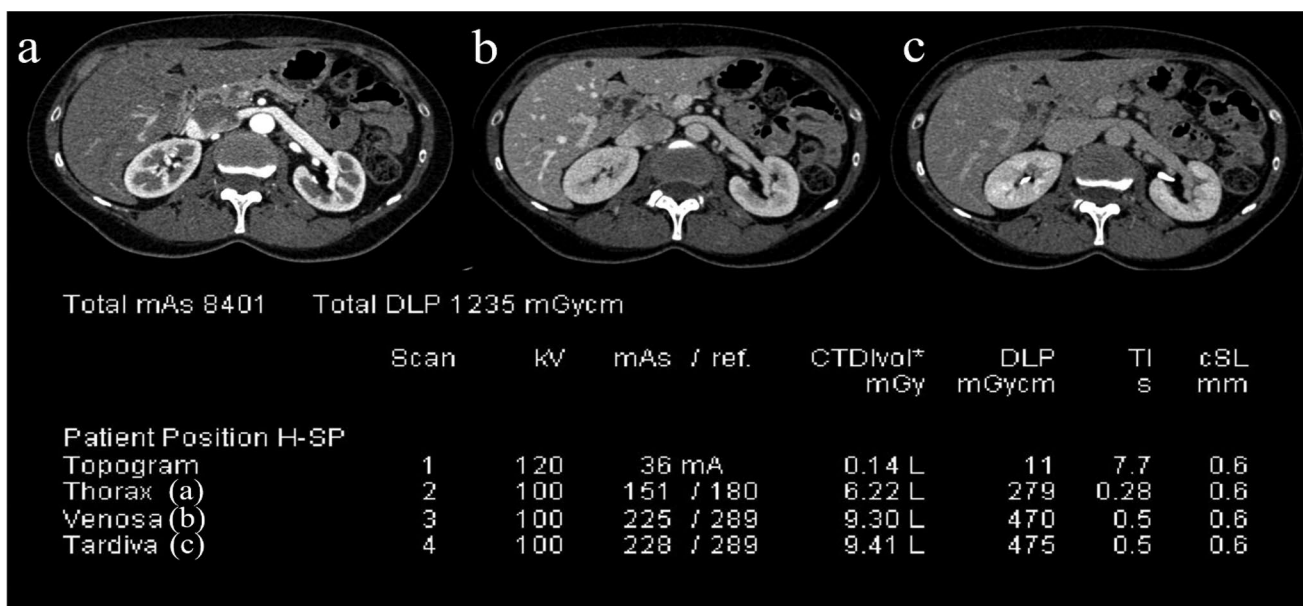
Female, 54 years old (55 kgs). Triple-phase liver CT examination for a female oncological patient. Scanner Siemens Somatom Definition Flash. Arterial phase (a) uses fixed kV (100 kV) and tube current modulation (TCM) optimized for vascular enhancement. The same protocol is used for portal- (b) and equilibrium-phase (c), with fixed kV (100 kV) and TCM optimized for parenchymal enhancement
